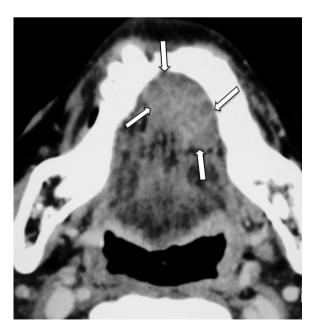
Axial contrast-enhanced CT scan showed a nonhomogeneously enhancing mass in the left side of the oral floor extending to the midline of the oral cavity (arrows).
